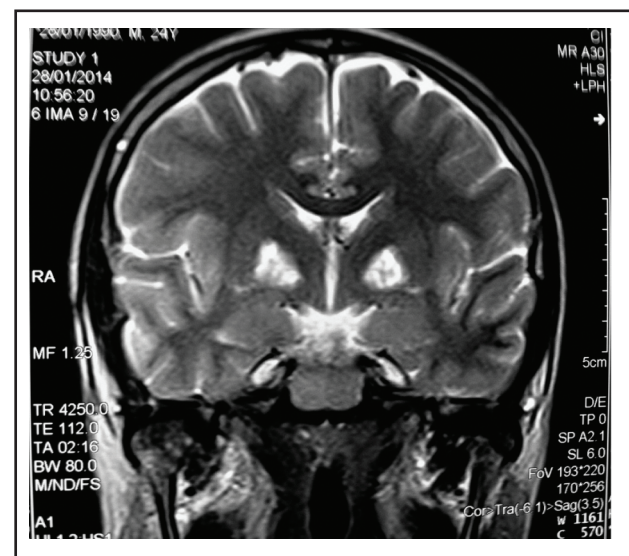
Coronal section T2 weighted MRI
